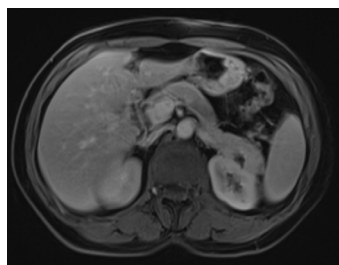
Post contrast images revealed a solid mass with central cystic area (Contrast-enhanced abdominal magnetic resonance images of the patient)
